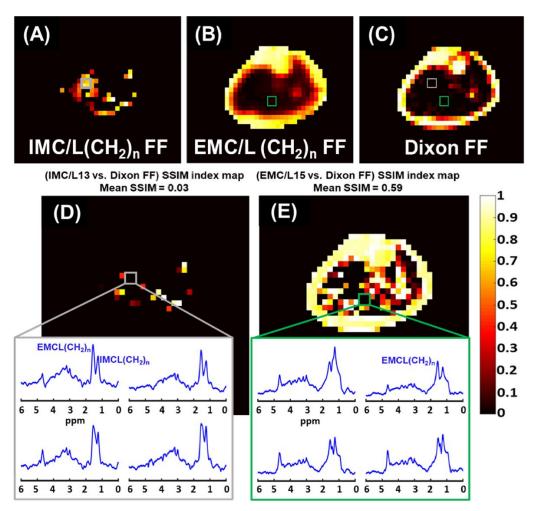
Fat fraction (FF) distribution maps of MRSI IMC/L(CH₂)_n (A), EMC/L(CH₂)_n (B), and the Dixon-MRI undifferentiated-fat-fraction image (C). The Dixon MRI image was down-sampled to MRSI resolution for a better comparison. The corresponding SSIM index maps show the structural similarity (SSIM) between the Dixon signal FF image and the MRSI IMC/L(CH₂)_n FF map (D), and the EMC/L(CH₂)_n FF map (E). The mean SSIM value is listed above each SSIM map. The dark areas of SSIM = 0 on the maps (box) represent total mismatching between MRSI and the used Dixon method results. Within these areas, only MRSI could identify lipid peaks
